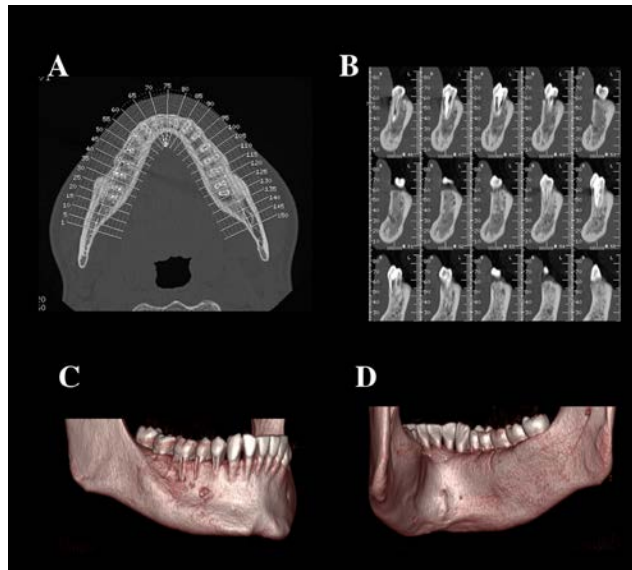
CBCT after two years of follow-up; total remission of multifocal osteolytic lesions is noted
